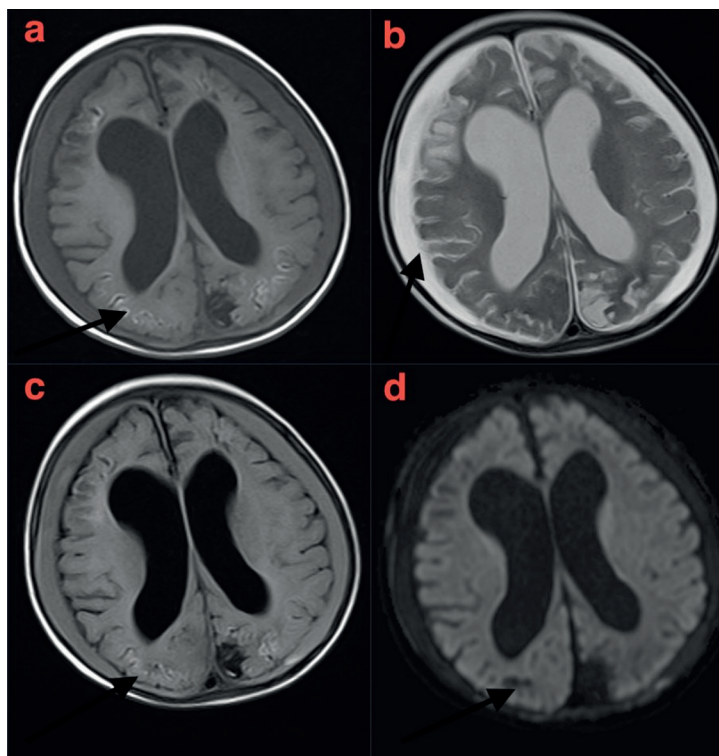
a. T1-Weighted axial b. T2-W axial c. FLAIR axial d. DWI Brain MRI Atrophy in the cerebral parenchyma, the lateral ventricles are dilated. T1 (a) and FLAIR (c) intense cortical-subcortical areas in the posterior parietal parenchyma, which do not have restricted diffusion in DWI (d). Fronto-parietal subdural effusion, that is intense in T1-W images according to cerebrospinal fluid (CSF) and iso-intense with CSF in T2-W images (b).
